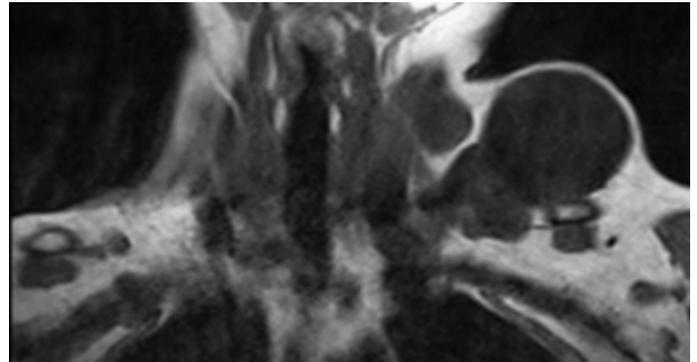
MR image, mediastinal extension suspected.
